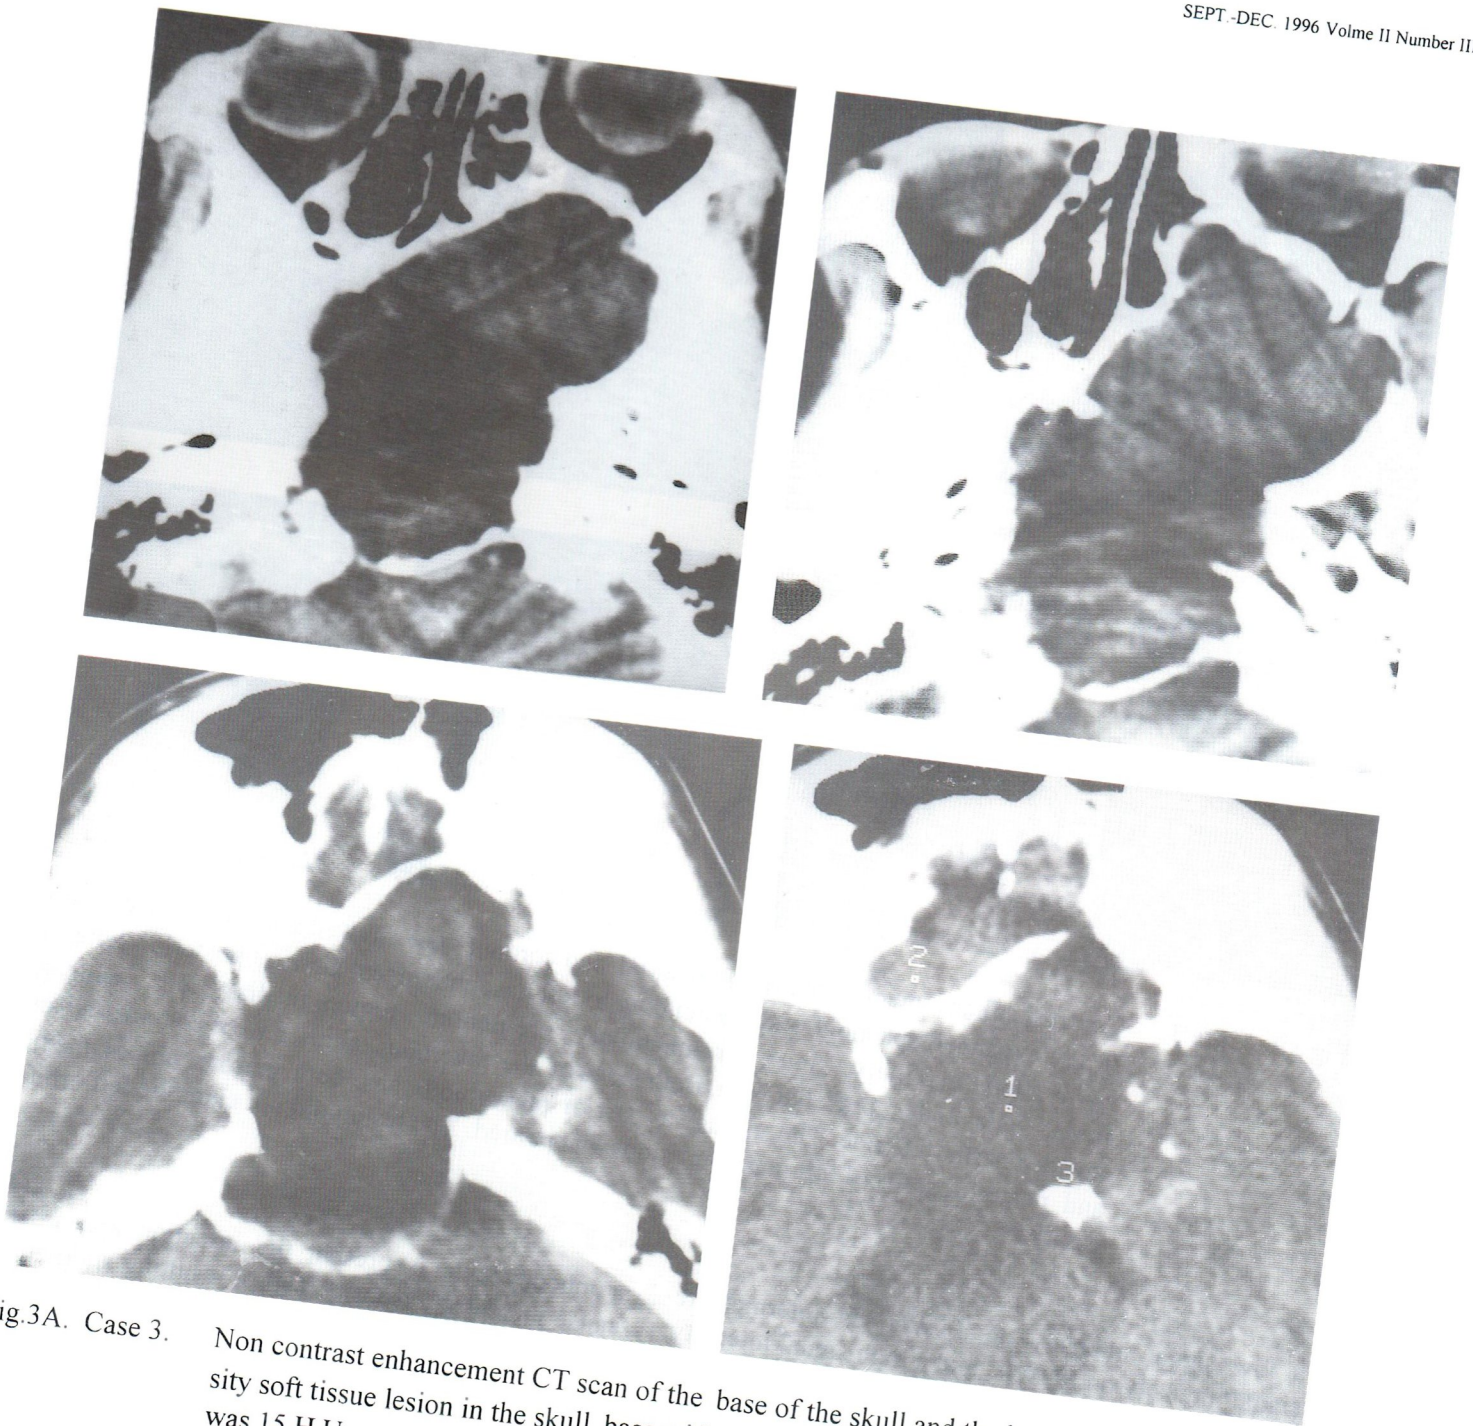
Case 3. Non contrast enhancement CT scan of the base of the skull and the brain revealed a low density soft tissue lesion in the skull base with intracranial extension. The density of the lesion was 15 H.U.
